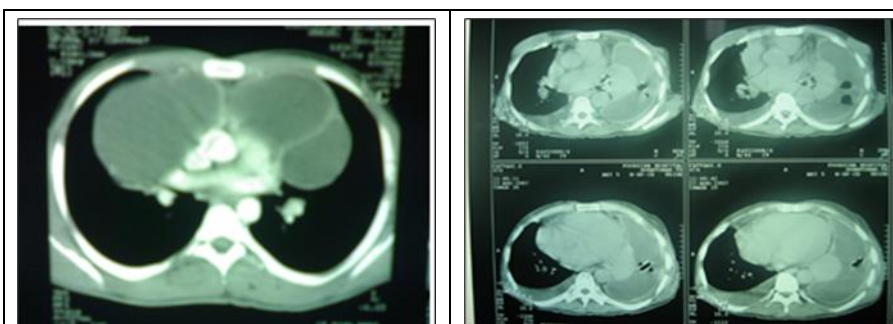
12 CT –scan bilateral thymic cyst and pleural effusion
